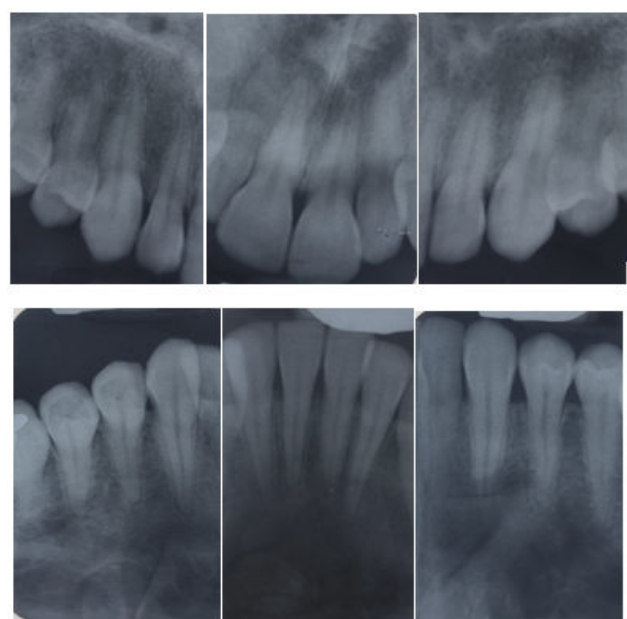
Baseline periapical radiographs.
